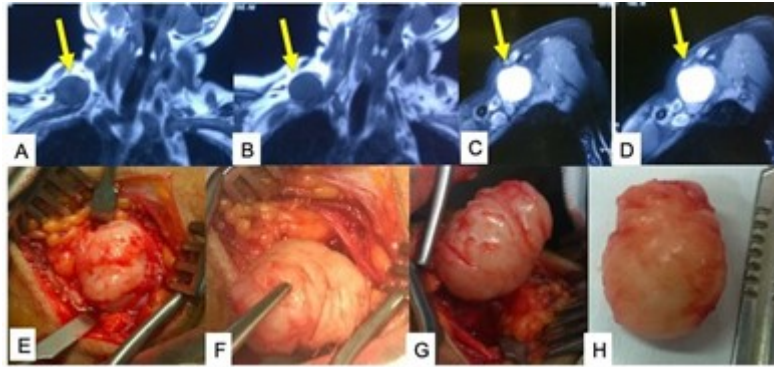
(A–D) MRI images showing a right brachial plexus schwannoma (arrow-marked). (E–H) Peroperative pictures of the removal of the schwannoma. Source: Figure by authors.
